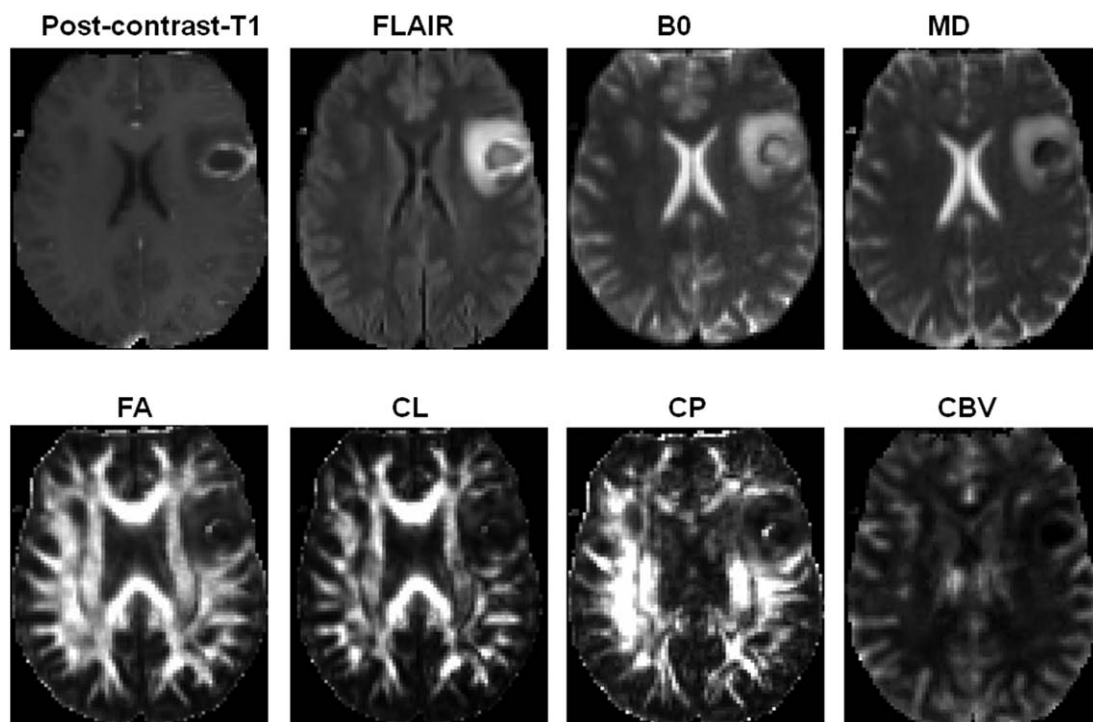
A 22-year-old patient with pyogenic abscess. An axial postcontrast  $T_1$ -weighted image demonstrating a ring-enhancing lesion in the left frontal lobe. This lesion demonstrates heterogeneous signal intensities on the corresponding FLAIR and  $B_0$  images, with moderate edema. The central core of the lesion shows low signal on MD map, and slightly high signal intensities on FA and CP maps, indicating anisotropic content. An enhancing region in the abscess wall demonstrates minimally elevated rCBV.
